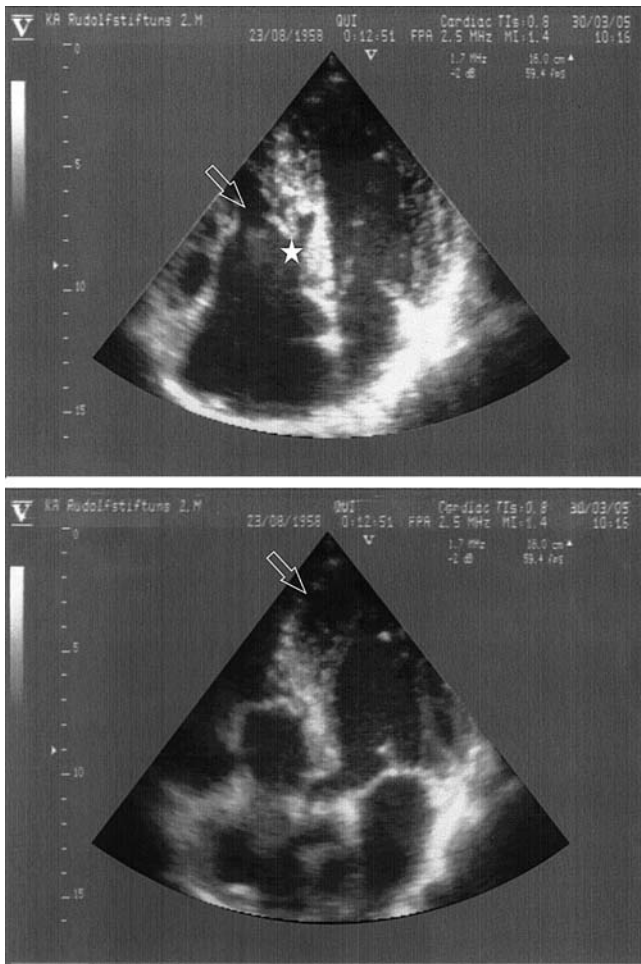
Upper panel: Echocardiographic apical four-chamber view showing apical displacement of the septal tricuspid leaflet (arrow) and a deep intramural recess of the atrialized portion of the interventricular septum within the right atrium (asterisk). Lower panel: Echocardiographic apical five-chamber view of the same patient, showing left ventricular hypertrabeculation/non-compaction of the left ventricular lateral wall, apex and interventricular septum (arrow).
